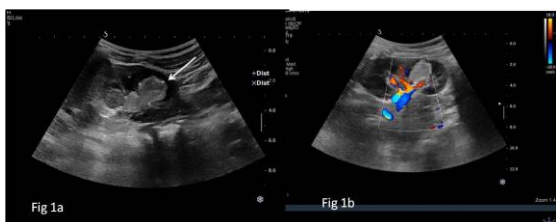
Grey scale and color Doppler ultrasound depicting echogenic mass lesion (arrow) in the lower pole of left kidney. Minimal vascularity is seen on color flow.
